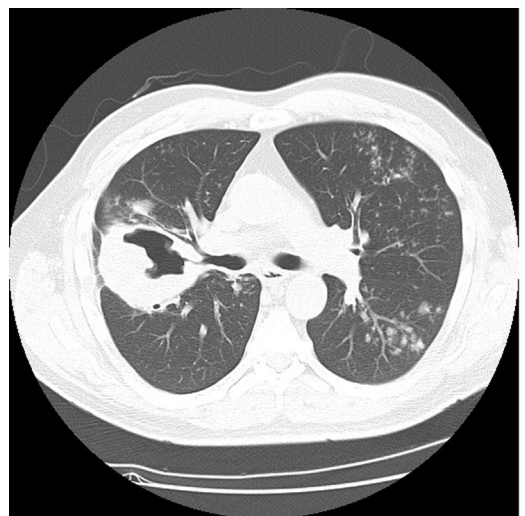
Chest CT in a patient with active pulmonary tuberculosis. Appearance similar to Fig. 3, fibrocavitary NTM, exemplifying the importance of microbiological evaluation.
